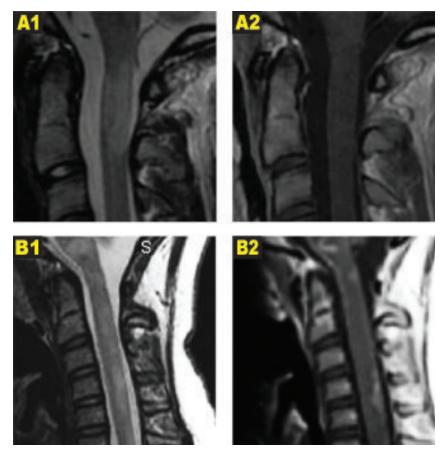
Figure (A&B): MRI of cervical spine with contrast was done
